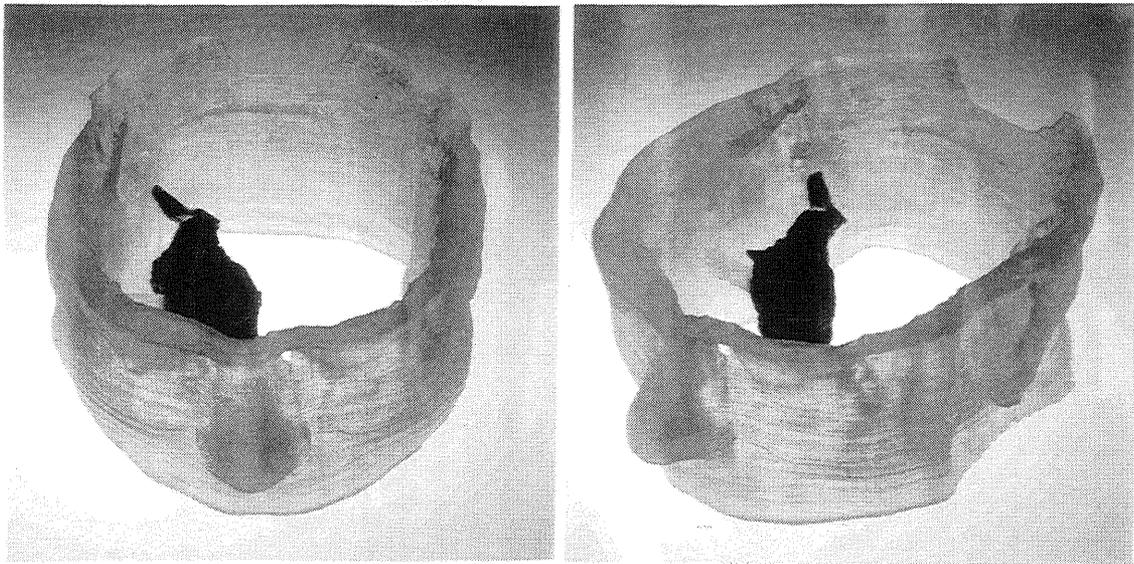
Dual color stereolithography model based on MRI with contrast.
